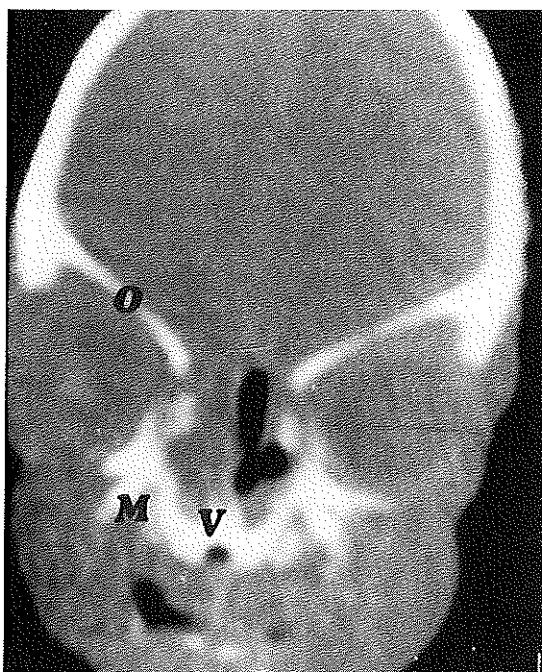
Coronal CT-scan of the human fetus of Fig. 9.1 and 2. Fixed in 0,1 M, phosphate buffered formaldehyde, pH 7,4. V: Vomer, M: Maxilla, O: Orbital roof. Note the "defect" in the base of the skull in the anterior fossa. The right nasal fossa is filled with meconium. (Philips Tomoscan 350, section thickness 1,5 mm)
